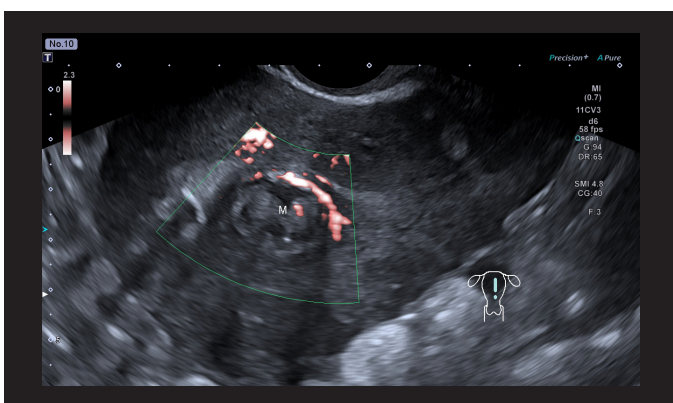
SMI appearances of an intramural myoma ("M") demonstrating typical peripheral and internal vascular patterns – emphasising the value of colour Doppler studies enabling differentiation between myomas and adenomyomas in particular.
